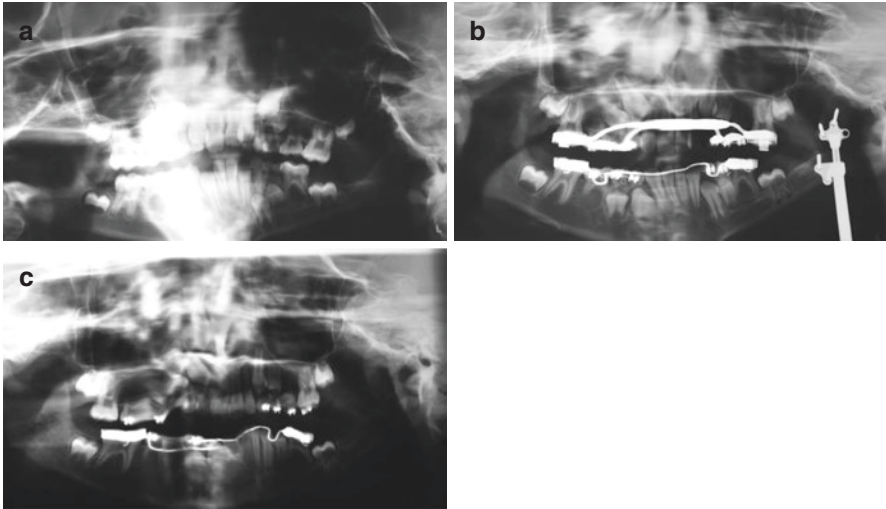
(a–c) Panoramic radiograph series before (a), during (b), and after (c) the left-side unilateral mandibular distraction. Note that the patient has a maxillary expansion appliance, and a tooth bud was enucleated 6 months prior to making the osteotomy and device placement. Following device removal, there is a resulting posterior open bite on the operated side
